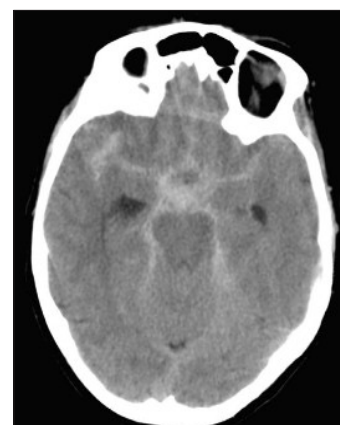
Axial computed tomography image of a typical subarachnoid haemorrhage.
